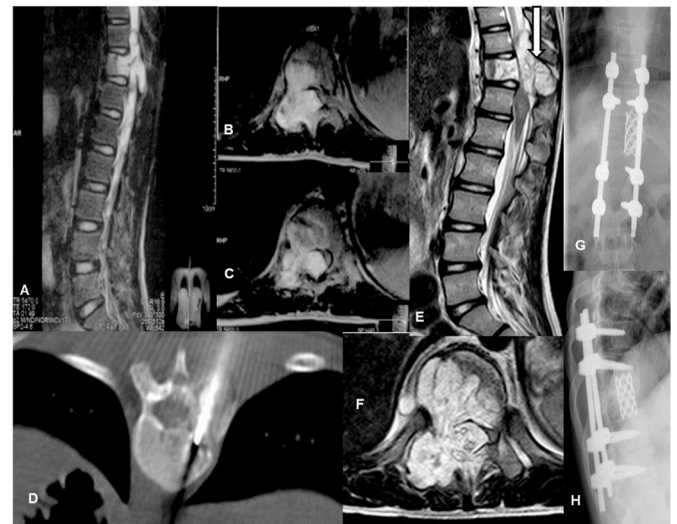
A 35-year-old male with progressive spastic paraparesis. A: Sagittal T2w MRI showing a hyperintense mass involving the posterior aspect of T11 vertebral body and posterior elements extending into the spinal canal. B & C: Axial T2w images showing destruction of the pedicle and posterior elements on the right-side D: He underwent a CT guided transpedicular alcohol injection. E & F: 6-month follow-up MRI showing disease progression prompting a T11 corpectomy and fusion. G & H: 1-year postoperative X-rays.
